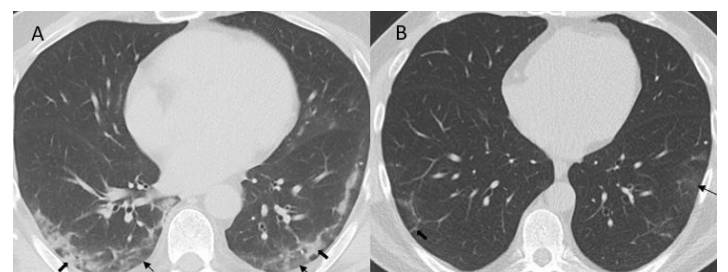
60-year-old man hospitalized for COVID-19 pneumonia. A) Baseline axial CT showing bilateral band-shaped consolidation (thick arrows) and ground glass opacities (thin arrows) with peripheral distribution. B) 3-month follow-up axial CT demonstrating the complete resolution of consolidation, with residual discrete bilateral subpleural reticulations (thick arrow) and discrete ground glass opacifications (thin arrow).
